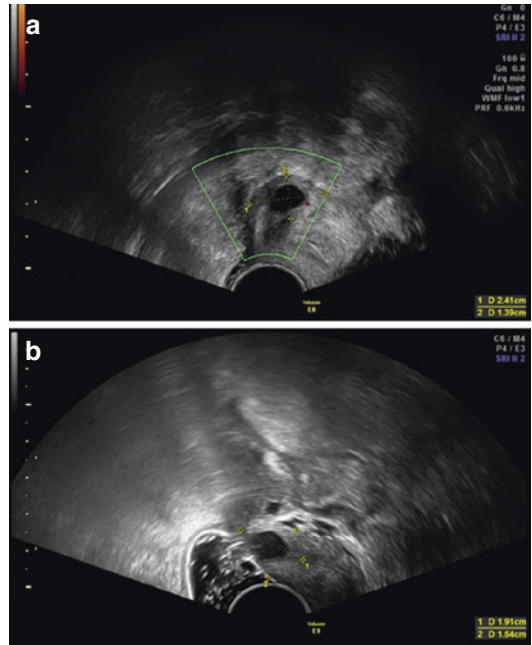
A forniceal nodule as visualized using plain transvaginal ultrasonography (a) and using tenderness technique (b)
